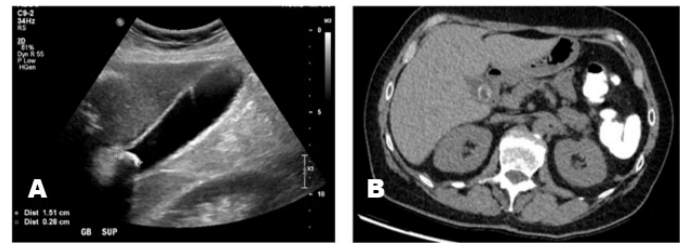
(A) Post-ileostomy gallbladder ultrasound and (B) axial CT abdomen slice in a 56F (Case 1) demonstrating evidence of acute cholecystitis with thickened gallbladder wall and trace pericholecystic fluid.
